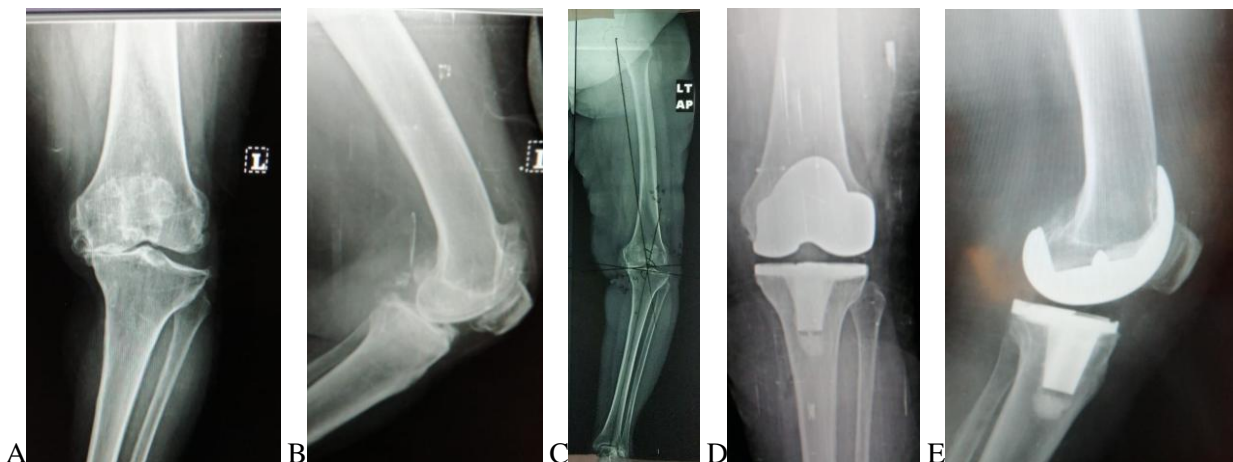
(A-E): preoperative and 1 year follow up X-ray female patient, 15° varus and 10 ° flexion deformity, gap balance achieved with the first 3 steps of release and no release of superficial MCL
